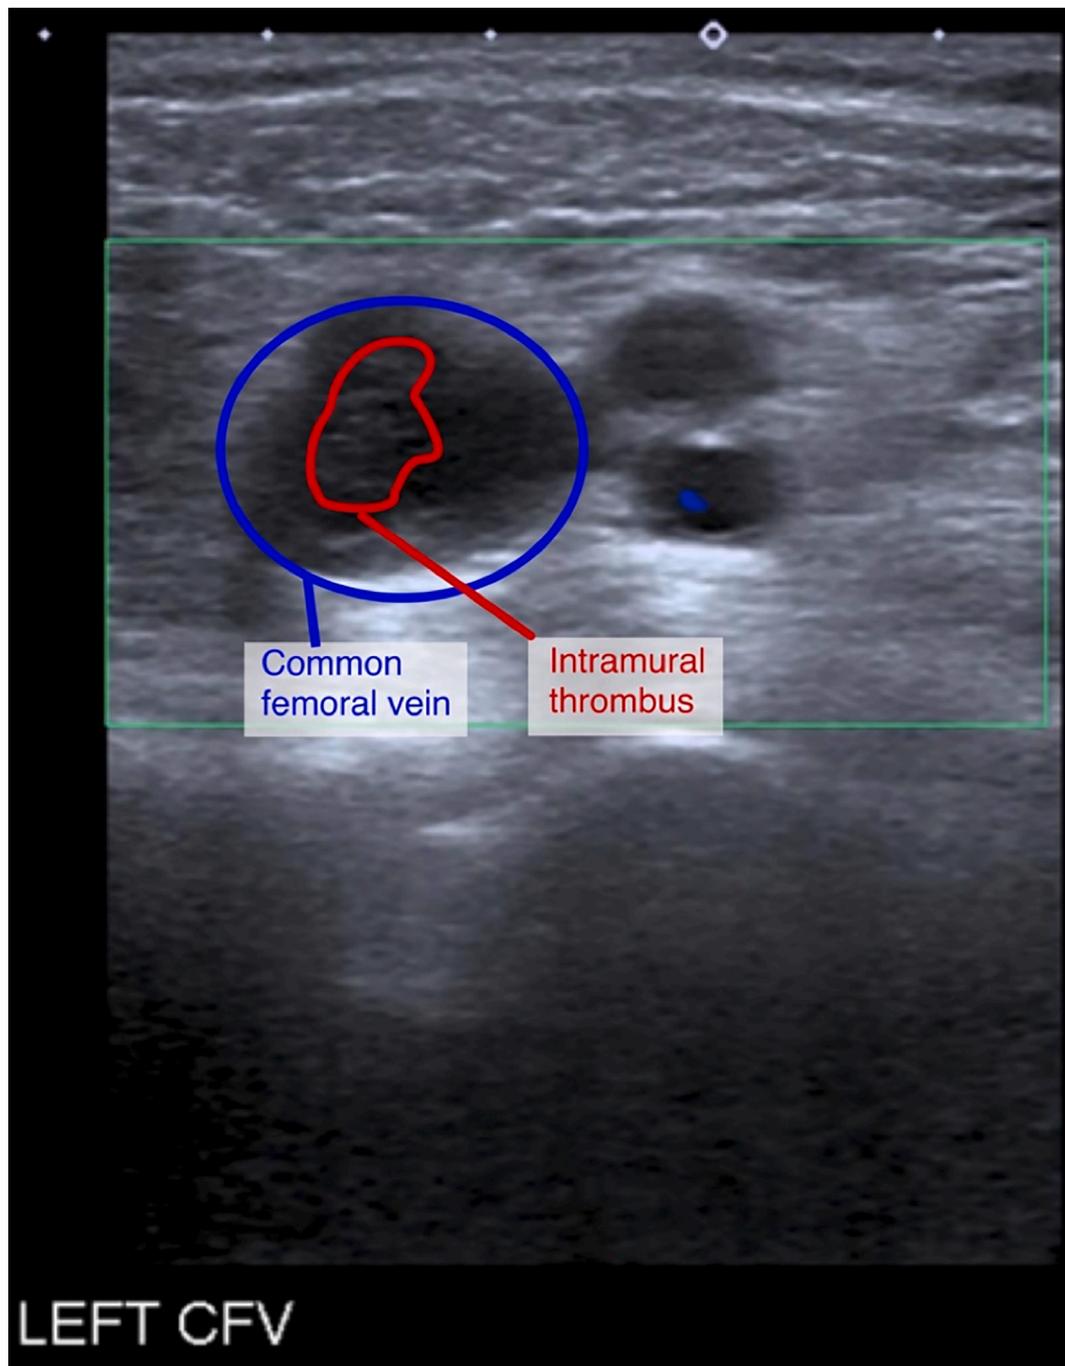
Doppler ultrasonography showing acute deep venous thrombosis at the common femoral vein.
